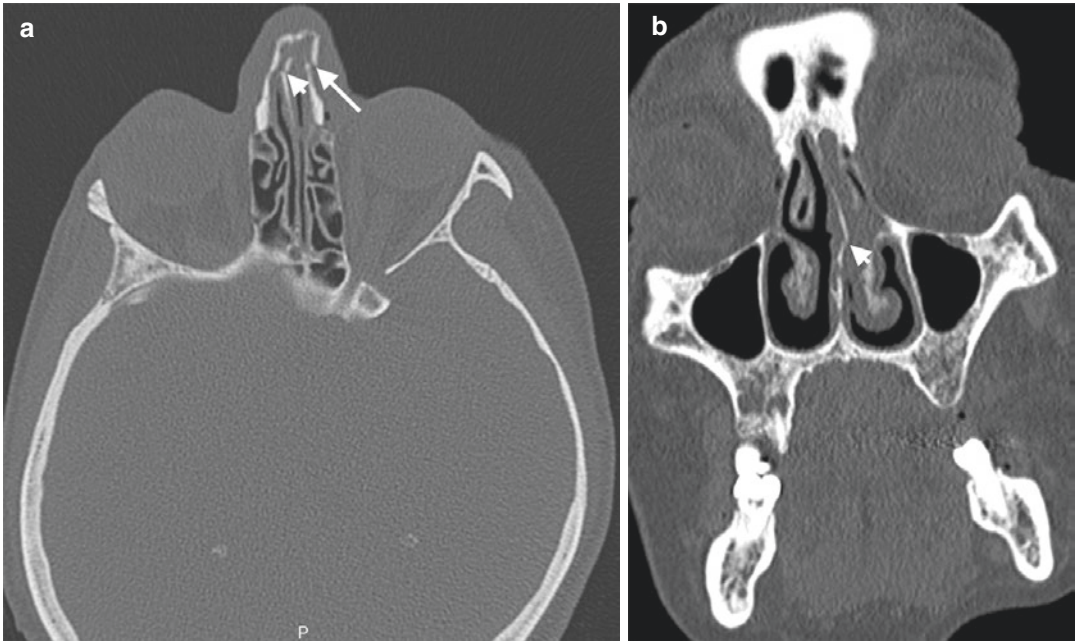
Nasal bone and septum fracture in a 50-year-old woman with a history of assault. Axial (a) and coronal (b) CT images demonstrate fracture of nasal bone (arrow) and nasal septum (arrowheads)
